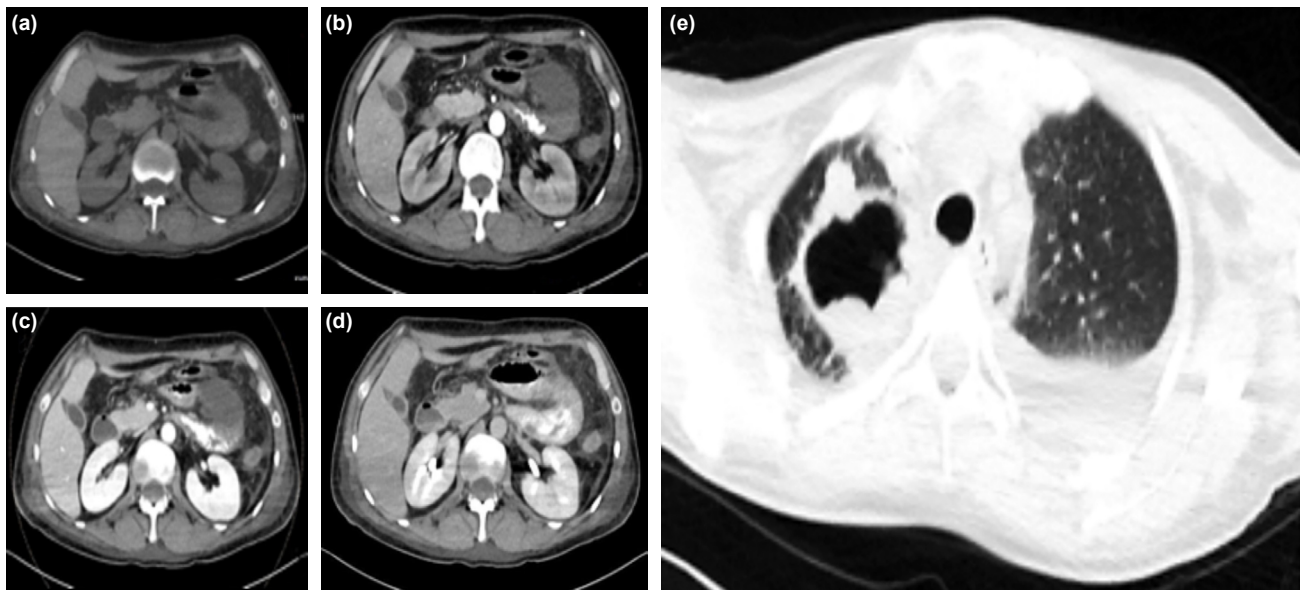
(a) Abdomen CT: Pre-contrast phase, (b) Abdomen CT: Arterial phase, (c) Abdomen CT: Portal phase, (d) Abdomen CT: Late phase, In the pre-contrast phase, the contrast agent is not visible in the intestinal lumen. In the other phases duodenum 3–4. Appears to begin to escape into the intestinal lumen, consistent with active bleeding from the continental level, (e) Thorax computer tomography (CT): Cavitory lesion in the lung.
